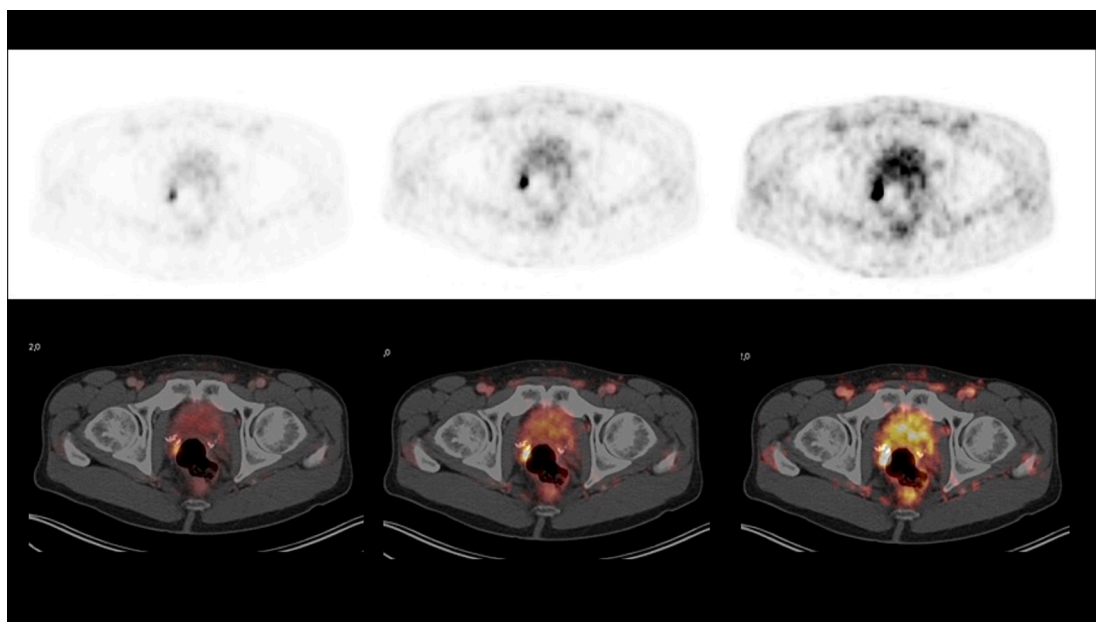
^{68}Ga - PSMA & CT images of a suspect lesion at the right seminal vesicle bed (case 1). First row with Standardized Uptake Value (SUV) 0–10; second row with SUV 0–5 (standard), and third row with SUV 0–2.5. Images provided by Ulm University, Department of Nuclear Medicine.
